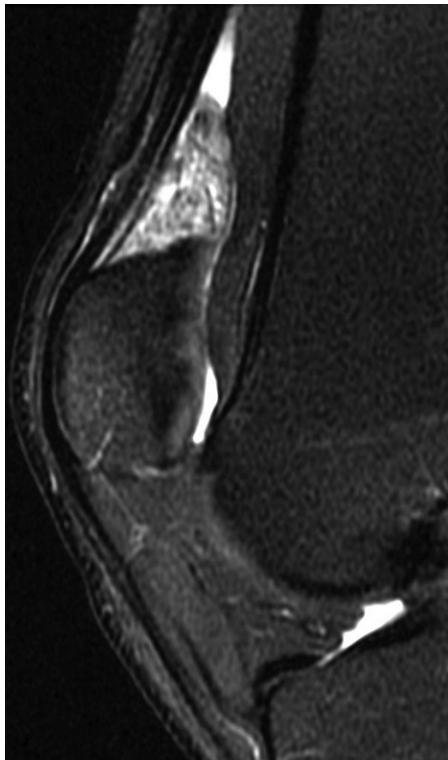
Quadriceps fat pad edema in a 27-year-old man with a 5-day history of atraumatic acute-onset knee pain with tenderness, which was located predominantly at the medial and lateral joint lines at physical examination. Sagittal PD-weighted fat-suppressed MR image shows suprapatellar fat pad edema without any other abnormalities. The edema was managed conservatively, and the symptoms resolved spontaneously.
